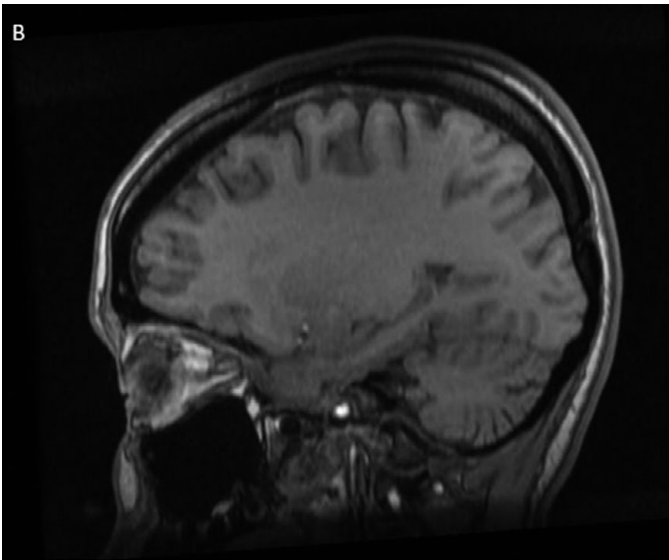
Simple sagittal MRI of the brain showing a generalized decrease in cortical and subcortical cerebral and cerebellar parenchyma.
